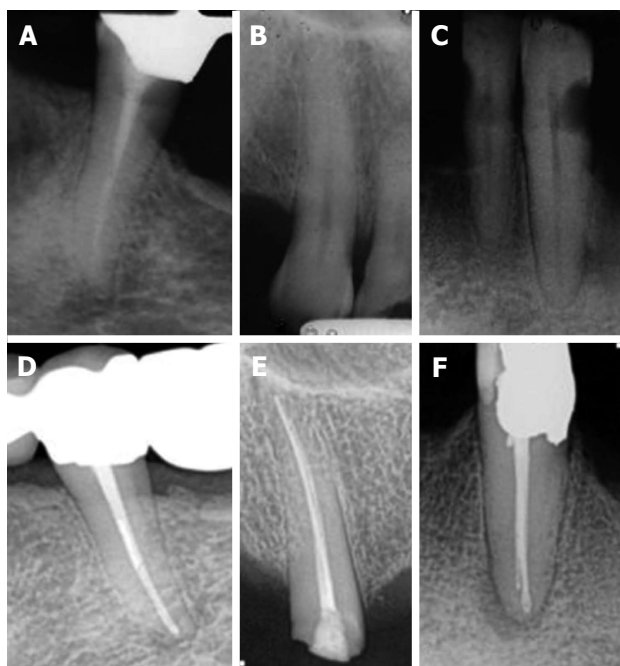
(A-C) preoperative and (D-E) 5-year follow-up radiographs: (D) complete healing, (E) uncertain healing, and (F) no healing.
